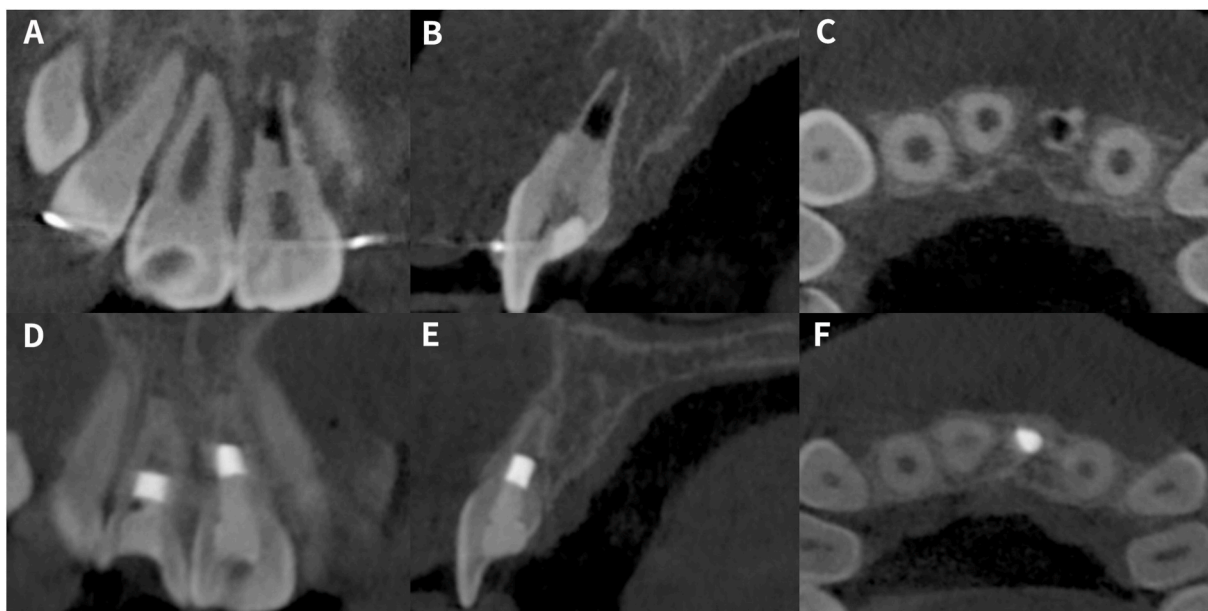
Cone-beam computed tomographic (CBCT) images of teeth 8 and 9 in the previous figure. (A) The coronal view showed apical radiolucency present in tooth 9 with accompanying mesial root perforation. (B) The sagittal view showed the thin buccal and palatal bony plates of tooth 9. (C) The axial view showed mesial root perforation of tooth 9. (D) The coronal view of CBCT images of 24-month follow-up of tooth 9 and 12-month follow-up of tooth 8. There was resolution of the periapical lesion in tooth 8. Thickening of the root canal walls was observed for both teeth 8 and 9. The mesial root perforation in tooth 9 was repaired with hard tissue. (E) The sagittal view showed thickening of the buccal and palatal bony plates. (F) The axial view showed repair of mesial root perforation of tooth 9 with hard tissue. Reprinted with permission [37]. Copyright 2021, Elsevier.
